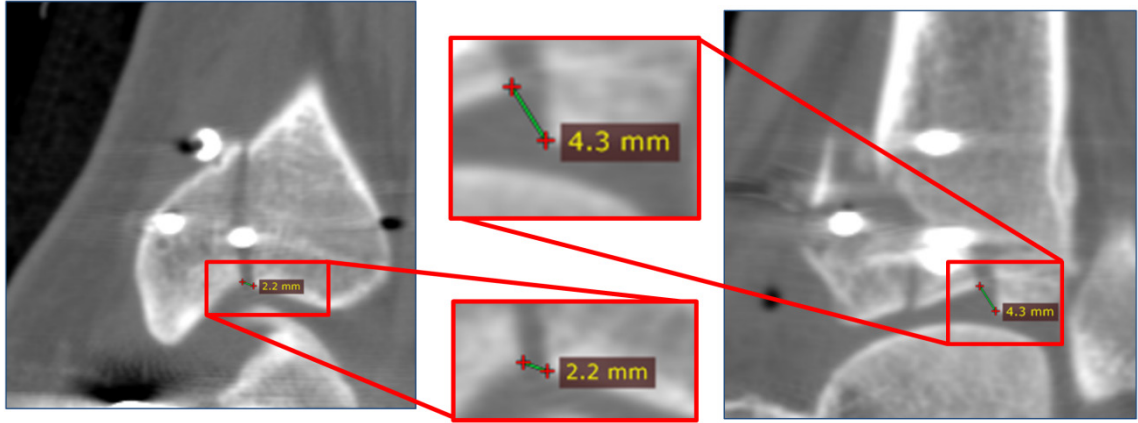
2D measurements performed manually by connecting the fracture edges of largest articular discontinuity of every slice in sagittal (left) and coronal (right) views. This is repeated for all CT slices containing fractured articular surface. The maximum value for each view is recorded.
